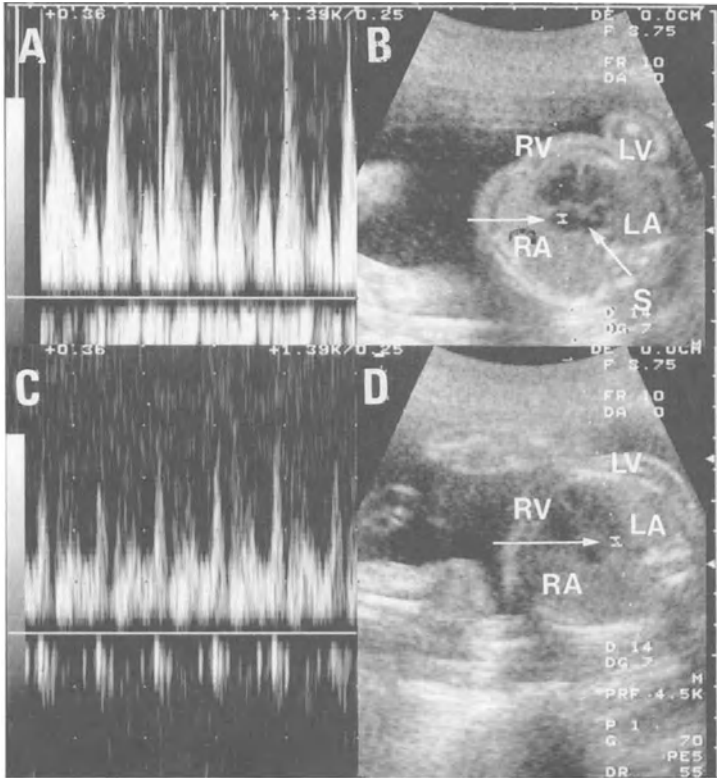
(A,B): Doppler characterization of right atrial flow in a normal fetus. S indicates the location of the fetal spine. The upper right panel (B) shows the two-dimensional echocardiogram of the right and the left atria (RA,LA) with the foramen ovale demonstrated (oblique arrow) as an echo-free space in the middle of the interatrial septum. The Doppler sample volume, indicated by two short parallel lines next to the horizontal arrow, is located in the right atrial cavity. The right and left ventricles (RV,LV) are also visualized. The Doppler tracings (left panel, A), obtained from the right atrium, demonstrate phasic and turbulent flow patterns with relatively high-magnitude frequency shifts. Panels (C,D): Doppler characterization of left atrial flow in a normal fetus. The two-dimensional echocardiogram (right panel, D) shows the position of the Doppler sample volume (two short parallel lines, horizontal arrow) in the LA. The oblique arrow points to the valve of foramen ovale. The Doppler tracing (left panel, C) shows phasic flow patterns with complex turbulent flow velocity dynamics. Note also the relatively lower magnitude of the Doppler frequency shifts obtained from the LA compared with those from the RA.
